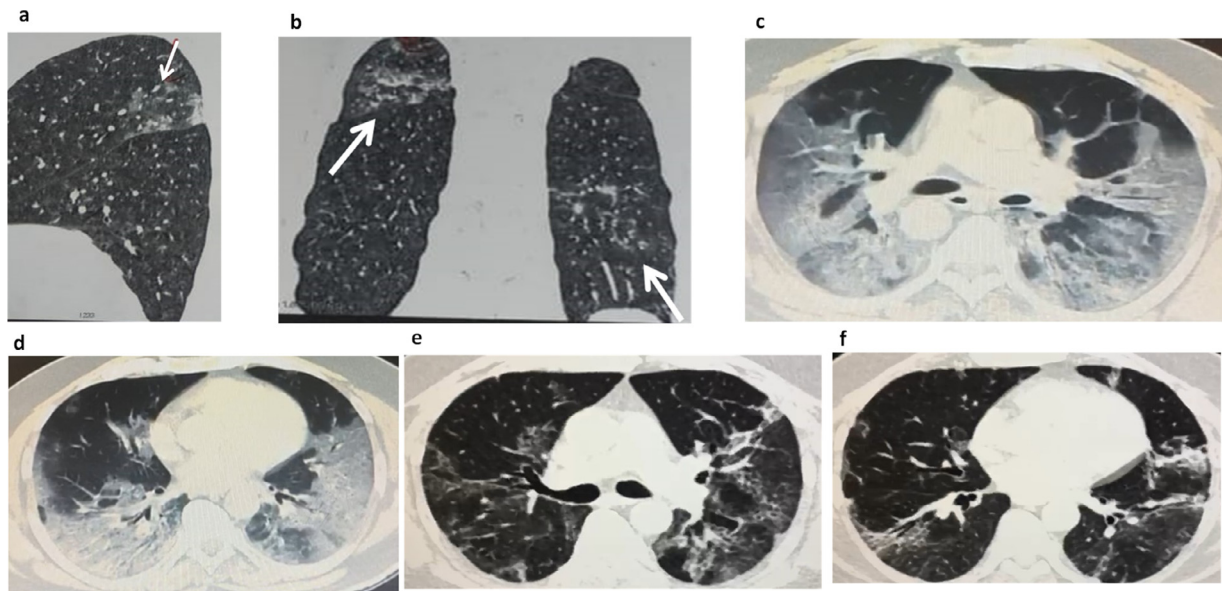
Temporal changes in COVID-19 pneumonia. (A,B) Sagittal and coronal reformatted CT chest in a 63-year-old patient who presented with cough and fever reveal mild patchy ground-glass opacities in bilateral lungs (arrows). (C,D) Repeat CT was done in the same patient after clinical worsening ten day's later. Axial images reveal radiological progression and confluent ground-glass opacities in bilateral lungs predominantly in dependent zones. Remdesivir was started at this point. (E,F) After 4 weeks from testing positive, follow-up axial CT reveals significant improvement with residual GGO, interlobular septal thickening and reticular opacities. (Color version of figure is available online).
